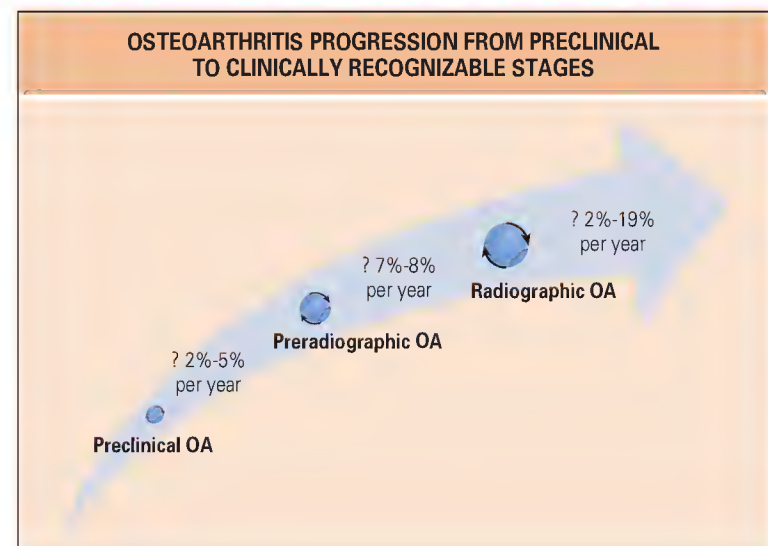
At present, rates of evolution from preclinical to preradiographic to radiographic osteoarthritis (OA) are not precisely known. After a severe acute knee injury, the annual rate of progression in the preclinical phase of OA must be at least 2% to 5% annually to account for the overall average risk for development of radiographic OA of 50% by 10 to 20 years later⁷; under less extreme circumstances the rate is probably lower. Knowledge of rates of progression to radiographic OA from preradiographic OA are limited but may be estimated at 7% to 8% annually given the current information available.²⁸ The rate of progression of radiographic OA to more severe radiographic stages is estimated to be 2% to 19% annually based on calculations using data from the placebo arms of a number of studies (summarized by Manno and colleagues³⁰). These figures should be treated as rough estimates in need of refinement through future longitudinal studies with more comprehensive patient phenotyping of different joints and patient subtypes and sensitive imaging and biochemical markers.
